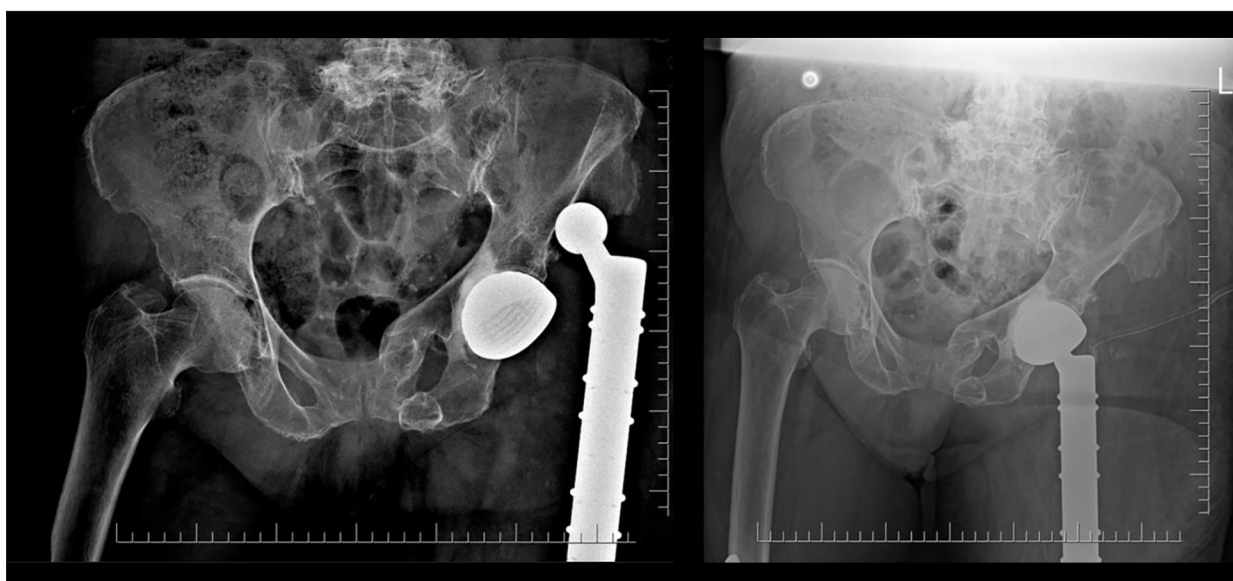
Radiographs of the left hip. Left: dislocation of the total femoral prosthesis. Right: successful reduction of the hip joint (7 months after presentation).
